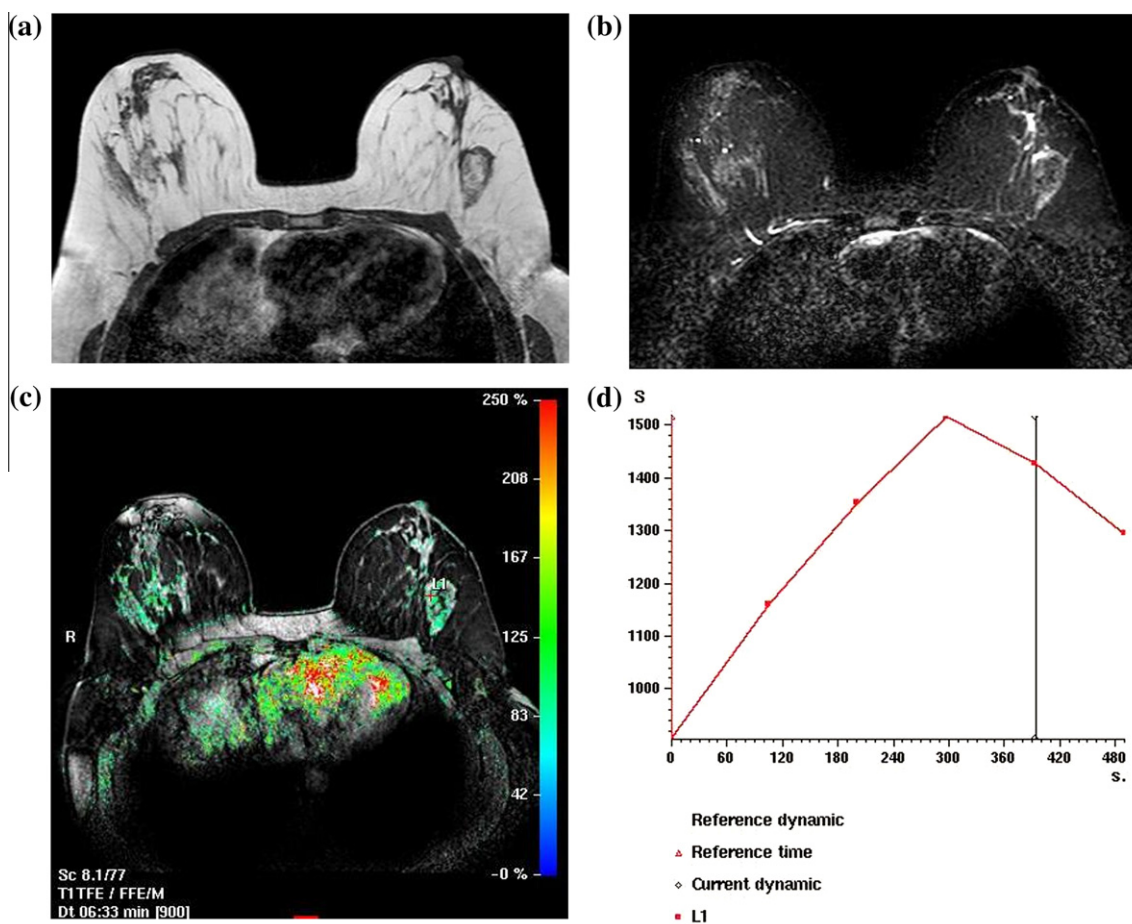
Left breast post malignant lumpectomy fat necrosis. Axial (a) T1-weighted and (b) T2-STIR that shows oval-shaped mass of fat-near SI related to the scar line that had been suppressed in (b) confirming fatty components. (c) Axial THRIVE image 8 min post contrast with color overlay shows heterogenous enhancement. (d) Time/SI analysis shows delayed peak of contrast uptake at 393 s. with corresponding SI% of 81% and type I benign curve pattern.
